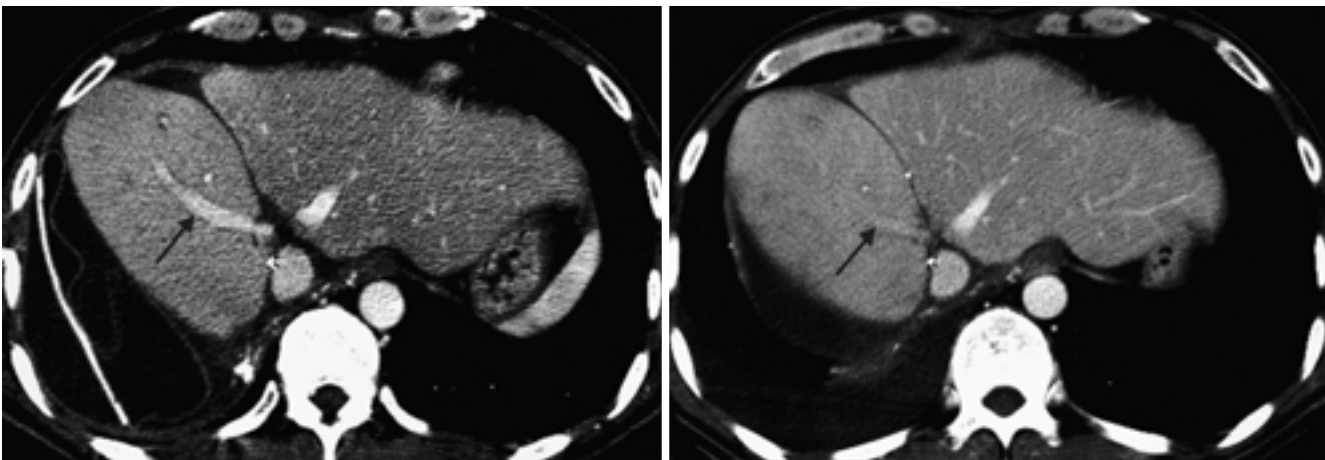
A. At 24th postoperative day, contrast-enhanced liver CT shows intact right hepatic vein (arrow) and normal hepatic attenuation. B. At 45th postoperative day, the right hepatic vein (arrow) was more thinner than at Fig. 1A. And the multifocal ill-defined low-attenuated areas are seen in the right liver.
